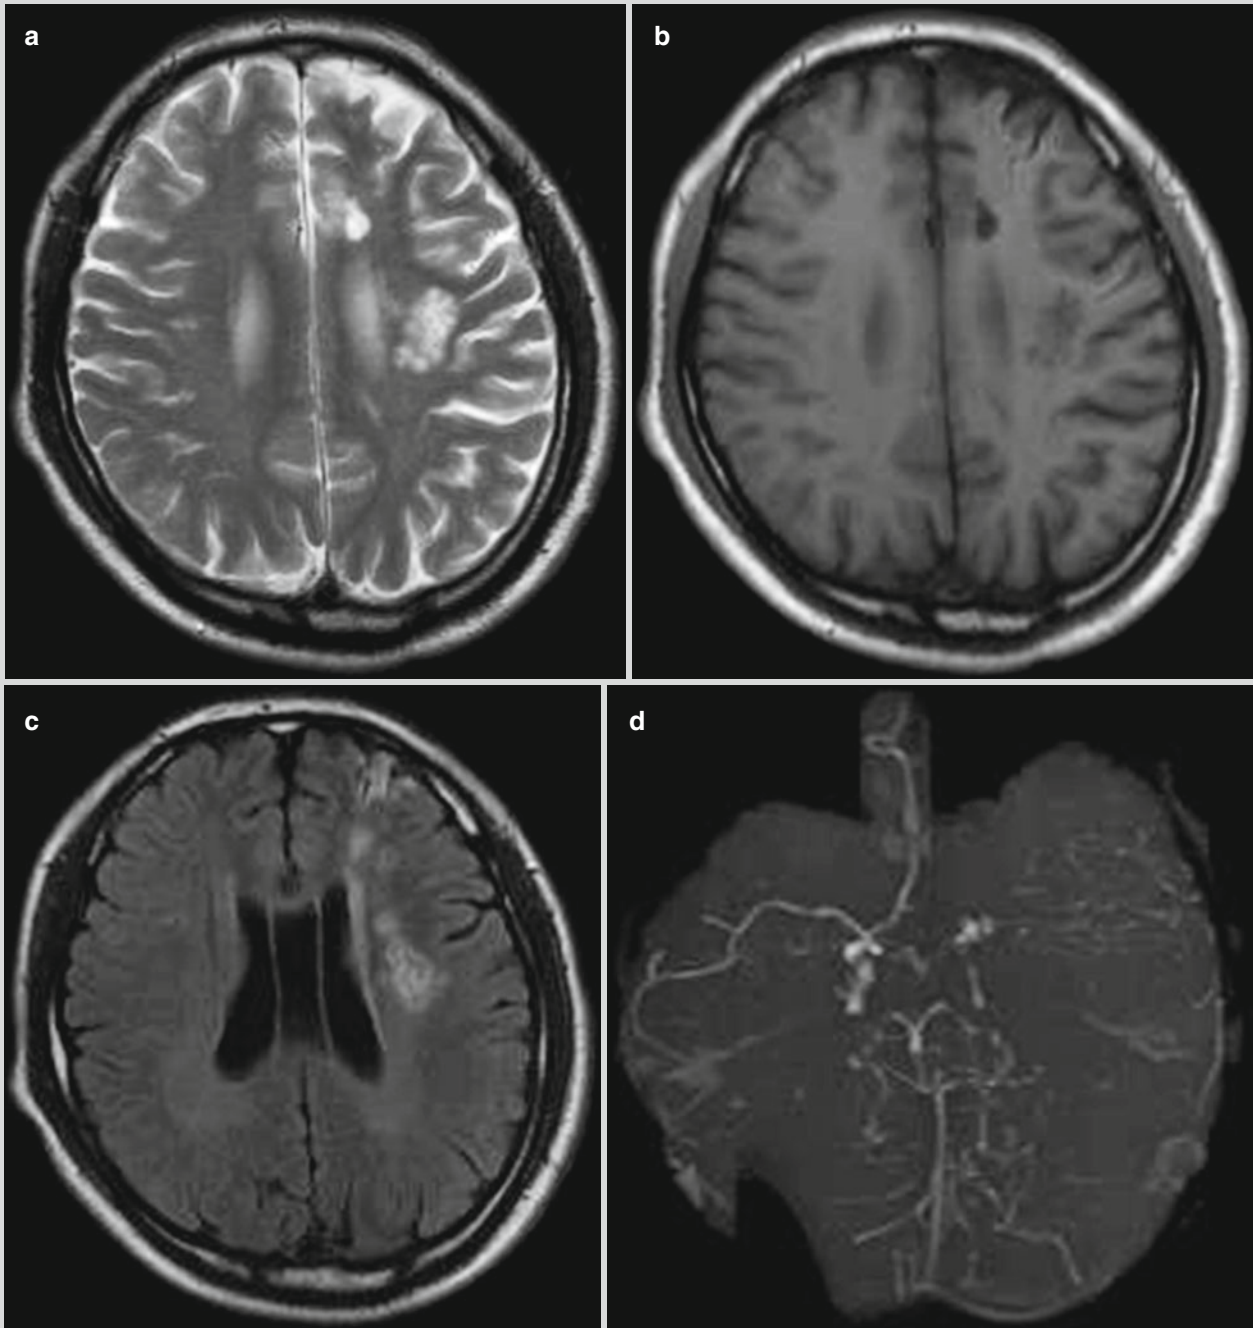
Neurological brucellosis. (a–d) MR imaging demonstrates multiple flakes of long T1 and long T2 signals at the left basal ganglia and the frontal lobe; uneven thickness of the left cerebral middle artery. The demonstrations indicate brucellar arteritis
